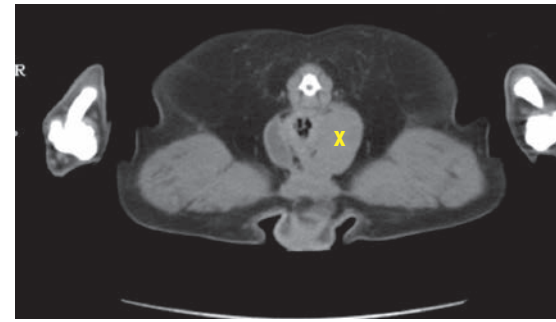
CT image showing a left sided anal sac adenocarcinoma marked 'x'.
